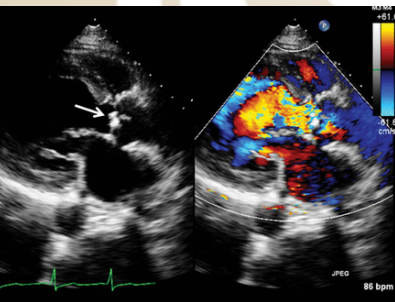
This is a parasternal long axis view showing vegetation on the aortic valve (arrow) and severe aortic regurgitation on an echocardiogram. (American Heart Association, 2013)
